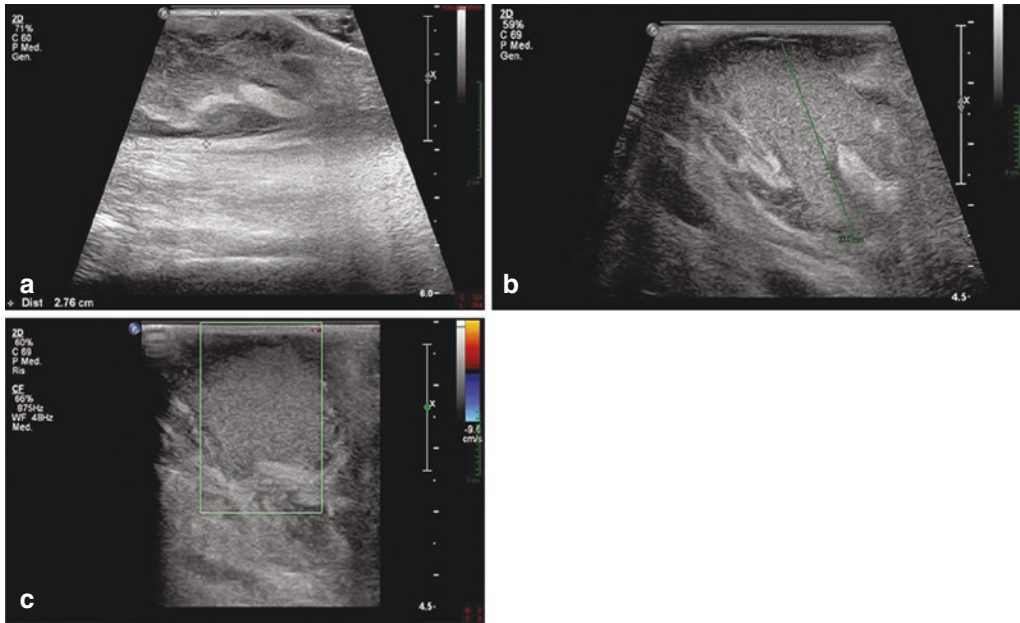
Right subcutaneous dorsal abscess in a 38-year-old diabetic male patient. Ultrasound examination (a, b, c) revealed a complex mass of about 3 cm in the axillary
